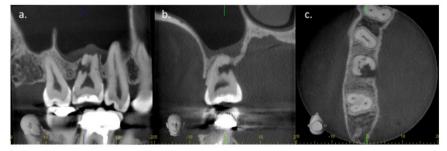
CBCT radiographs of extraoral apicoectomized complete root formation tooth with external inflammatory resorption. Sagittal (a.) coronal (b.) and axial (c.) images showed extensive external inflammatory resorption. Tooth was indicated to be extracted
